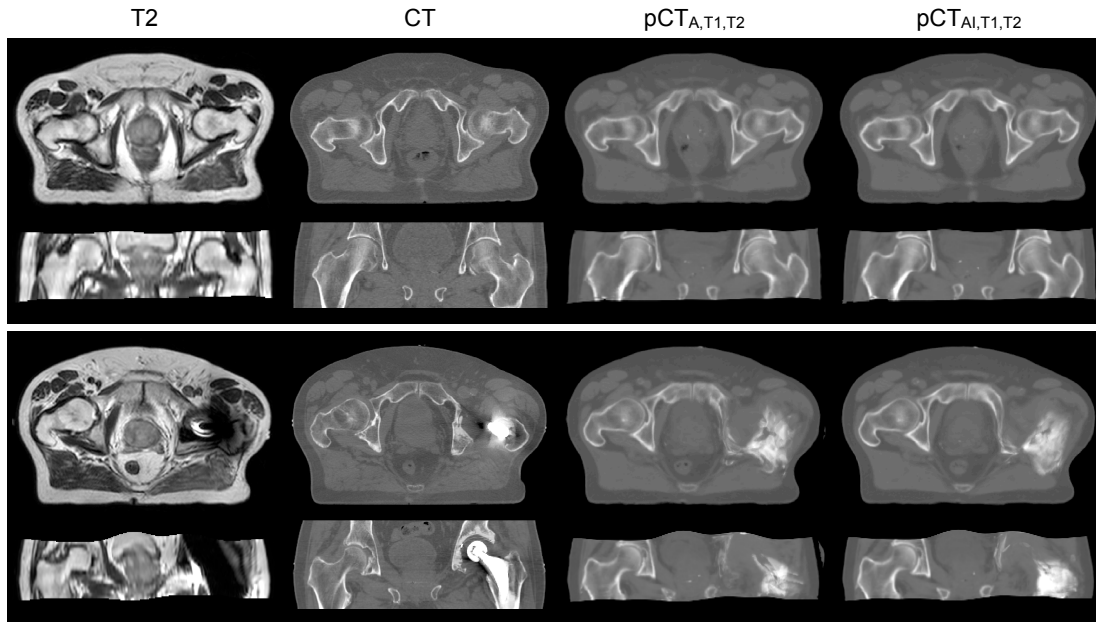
Examples of CT synthesis in the pelvic region for a representative subject (top) and a subject with a hip implant (bottom). From left to right: the T2 image, reference CT and pseudo CTs obtained from a T1-T2 pair using a single affine transformation before ($pCT_{A,T1,T2}$) and after ($pCT_{AI,T1,T2}$) bone refinement.
